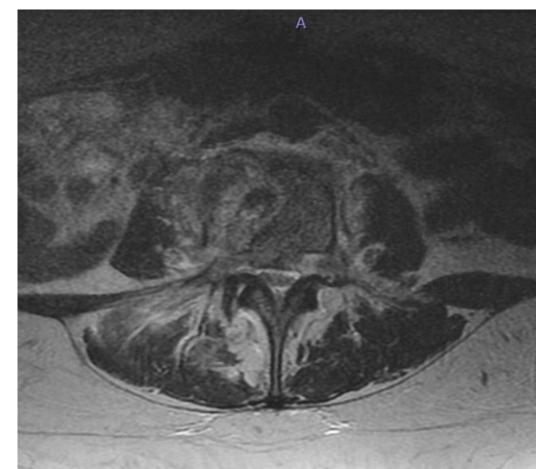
(Left): CT lumbar spine showed pathologic L4 compression fracture, possibly metastatic disease or multiple myeloma with retropulsion resulting in spinal canal and bilateral neural foraminal stenosis at L4-5
